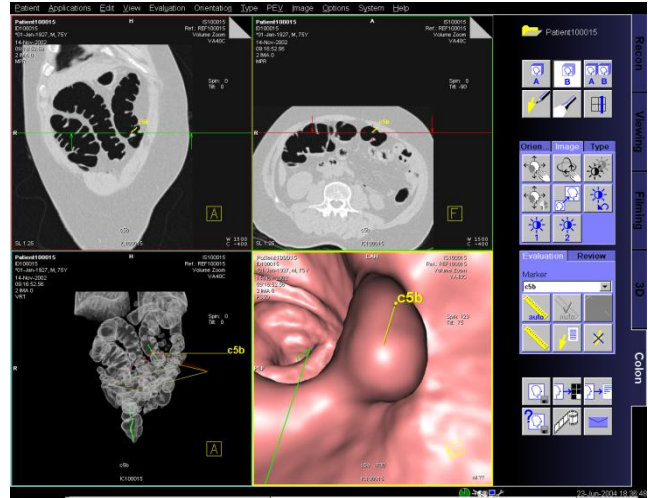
CT scan with enhanced visualization of a polyp in the colon.
